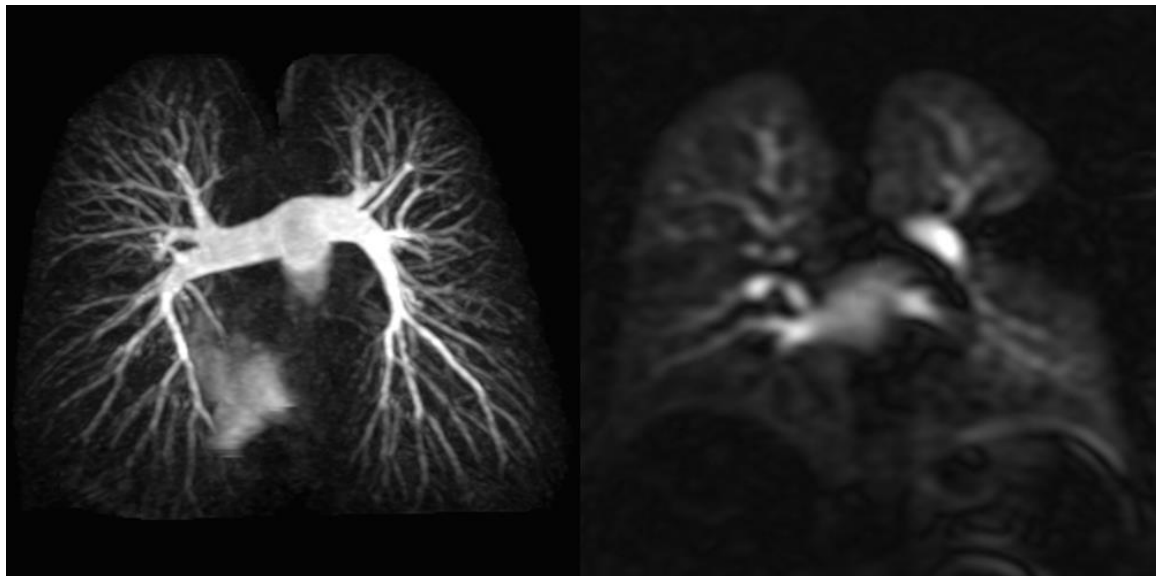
Contrast enhanced MRA and dynamic contrast enhanced MRI.
